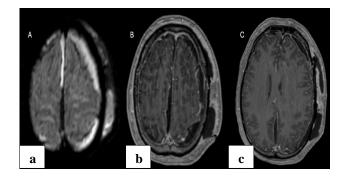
Post-craniotomy meningitis with subdural empyema (a) DWI shows restricted diffusion (ADC 0.4 × 10⁻³ mm²/s) in subdural collections along the left hemisphere, right frontal convexity, and interhemispheric fissure, and (b and c) T1 post-contrast sequences reveal peripheral enhancement of subdural collections (empyema), diffuse pachymeningeal and leptomeningeal enhancement (meningitis), and rim-enhancing scalp collection at the operative bed (abscess).
